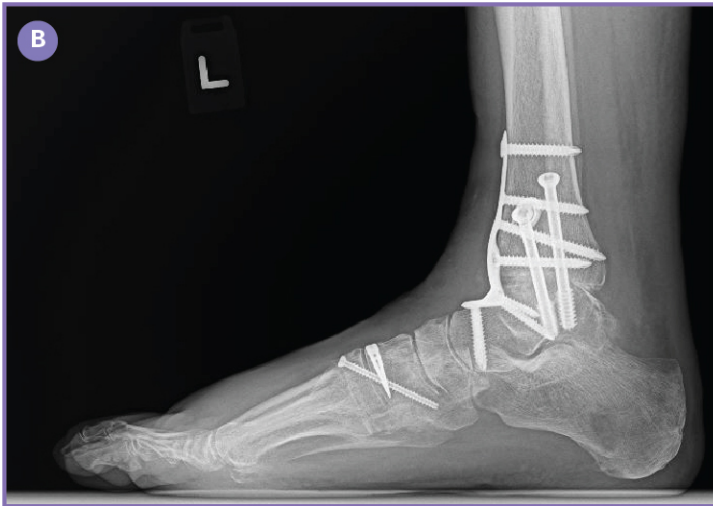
Weightbearing pre-operative radiographs demonstrating valgus ankle deformity with progressive arthritic change (A) AP and (B) Lateral.
